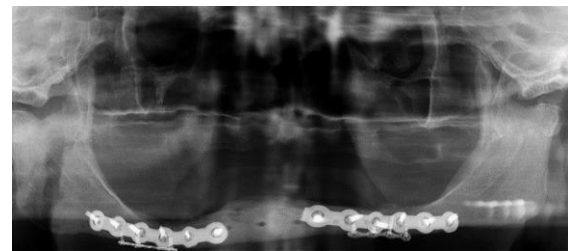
Postoperative radiographic evaluation of the parasymphysis fracture approach, 18 months before the bilateral fracture on the mandibular body region.
